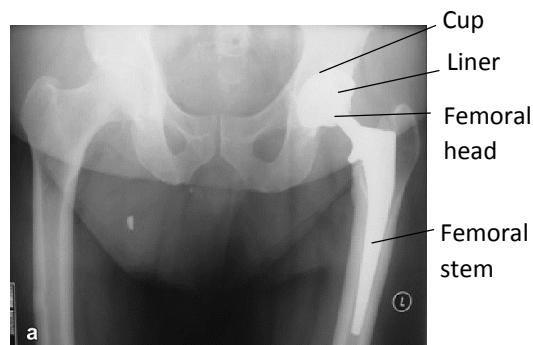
X-Ray of Patient with Hip Implant³
